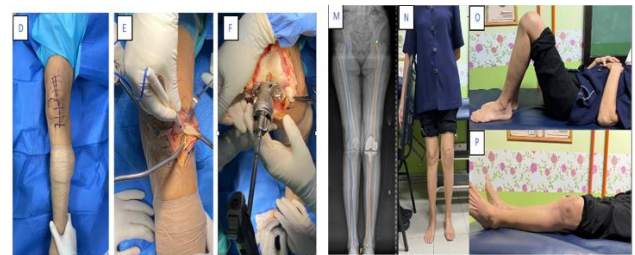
PS TKA with lateral parapatellar approach and inside-out technique lateral release. Radiograph; restoration of mechanical axis
